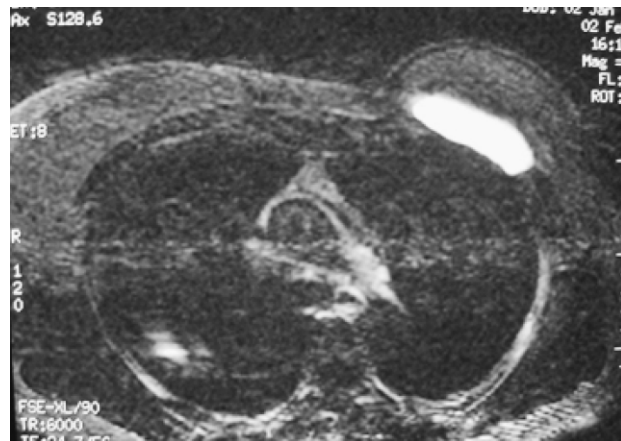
MRI scan of the thorax showing the silicone implant present on the left chest wall and having migrated postero-laterally.
